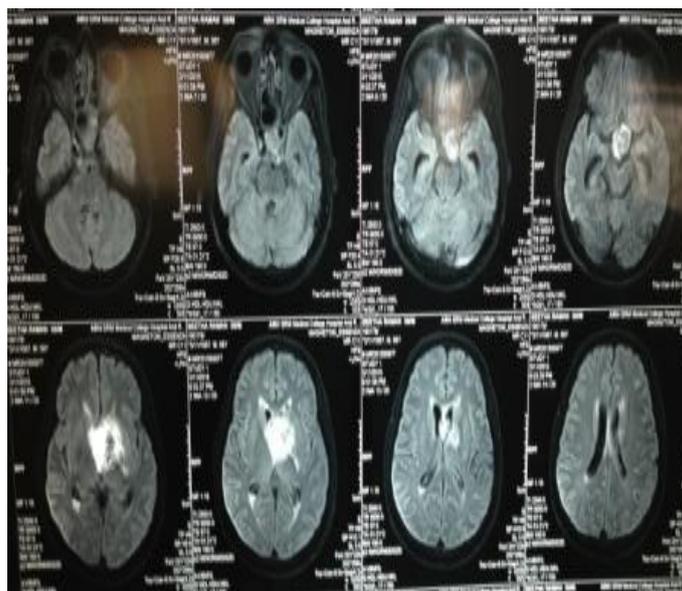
MRI brain coronal view showing pituitary hemorrhage
